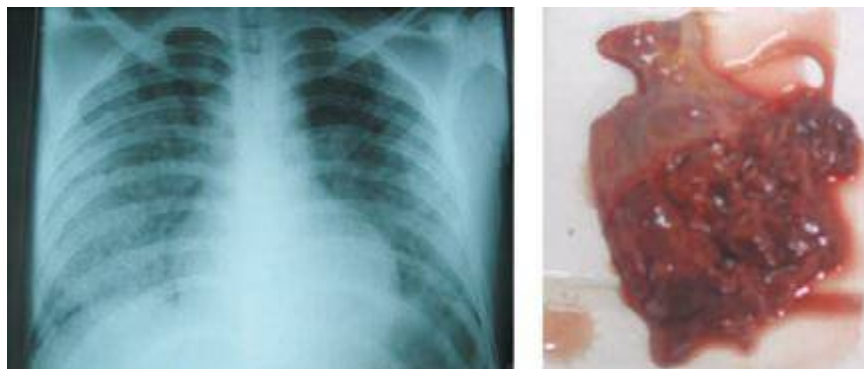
Severe pulmonary hemorrhage in leptospirosis. Left panel: Chest x-ray. Right panel: Gross appearance of right lower lobes of lung at autopsy. This patient, a 15-year-old from the Peruvian Amazonian city of Iqitos, died several days after presentation with acute illness, jaundice, and hemoptysis. Blood culture yielded *Leptospira interrogans* serovar Copenhageni/Icterohaemorrhagiae. (Adapted with permission from E Segura et al: *Clin Infect Dis* 40:343, 2005. © 2005 by the Infectious Diseases Society of America.)
